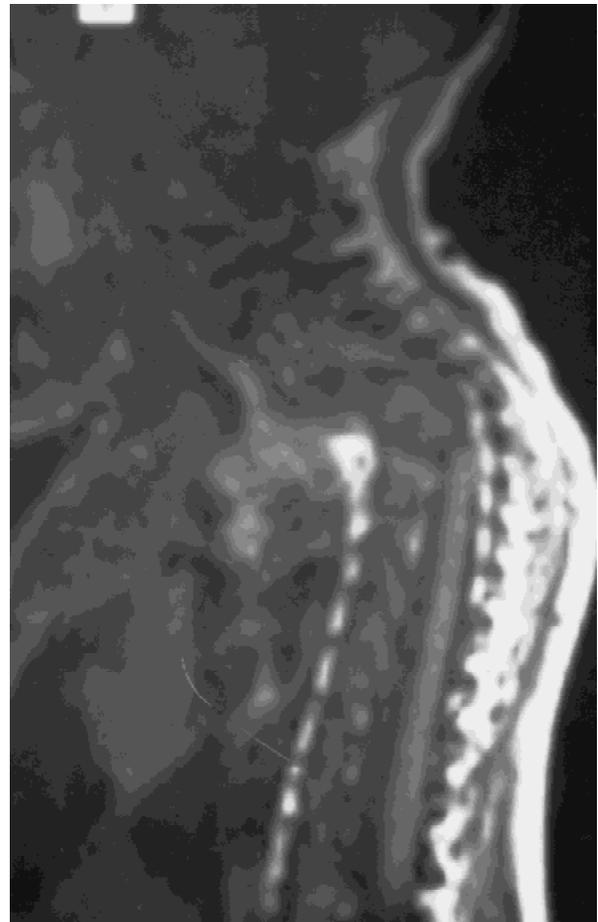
MRI scan of the spine of patient 1 at age 6 years. Striking gibbus-like bending of the lower cervical and upper thoracic spine is demonstrated. There is extreme stenosis of the spinal canal with compression of the spinal cord. Only a marginal part of the cyst within the dorsal groove of the skull is seen on this film.
